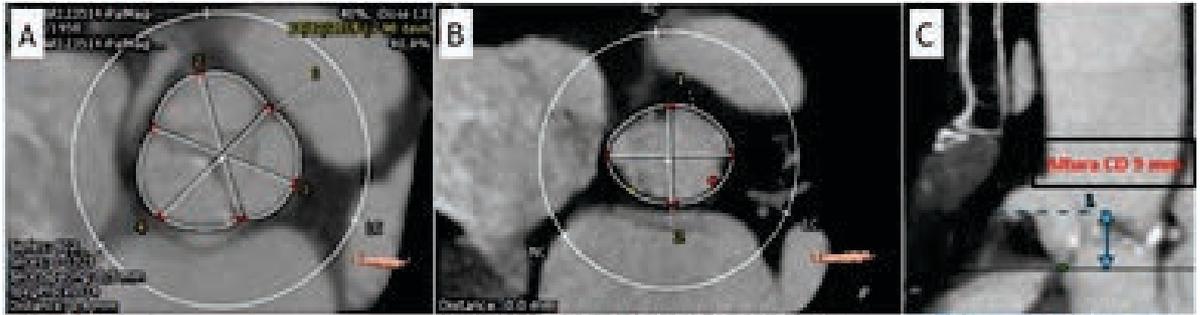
A - B) CT scan image of a calcified tricuspid aortic valve. C) Anomalous origin of the left main coronary artery from the right sinus.
